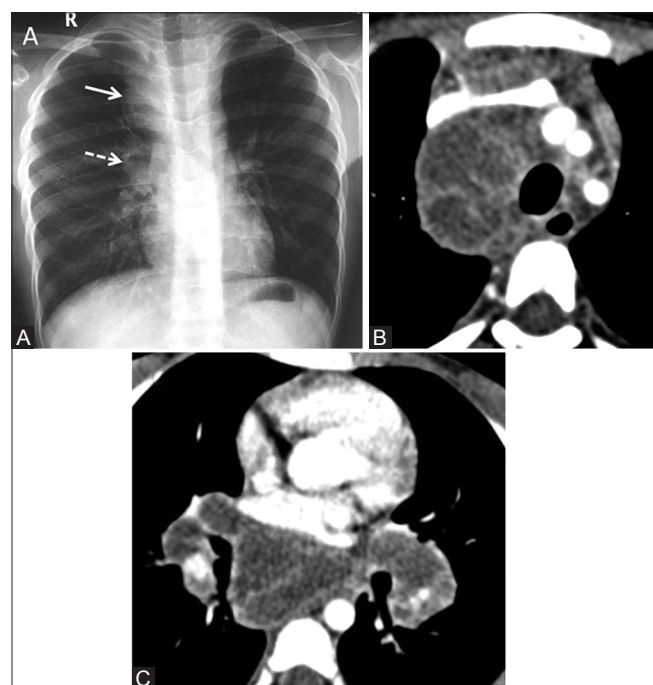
(A-C): Tuberculosis: Typical mediastinal lymphadenopathy. (A) Chest X-ray (CXR) showing right paratracheal (solid arrow) and unilateral right hilar lymphadenopathy (dashed arrow) without parenchymal abnormality. (B and C) Axial images of CECT chest (mediastinal window in another patient) show necrotic conglomerate lymph nodes in right paratracheal, bilateral hilar and subcarinal region with obscuration of perinodal fat showing "rim enhancement." Note asymmetrical involvement of bilateral hilar lymph nodes
